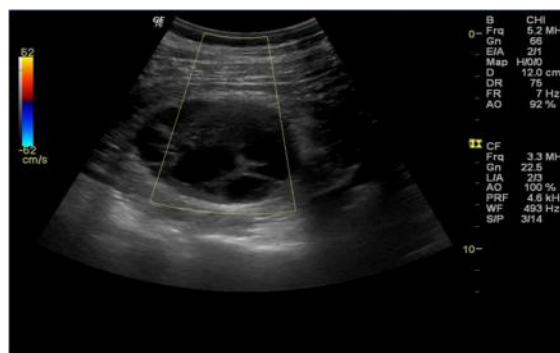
Multiseptated appearance of the hydatid cyst with absent color uptake on color Doppler imaging.
